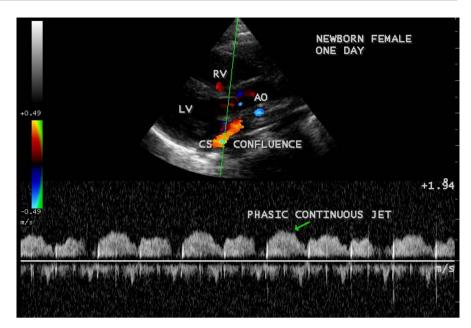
CW (Continuous Wave) Doppler Showing the phasic continuous jet of CS (coronary sinus) confluence in a newborn.
